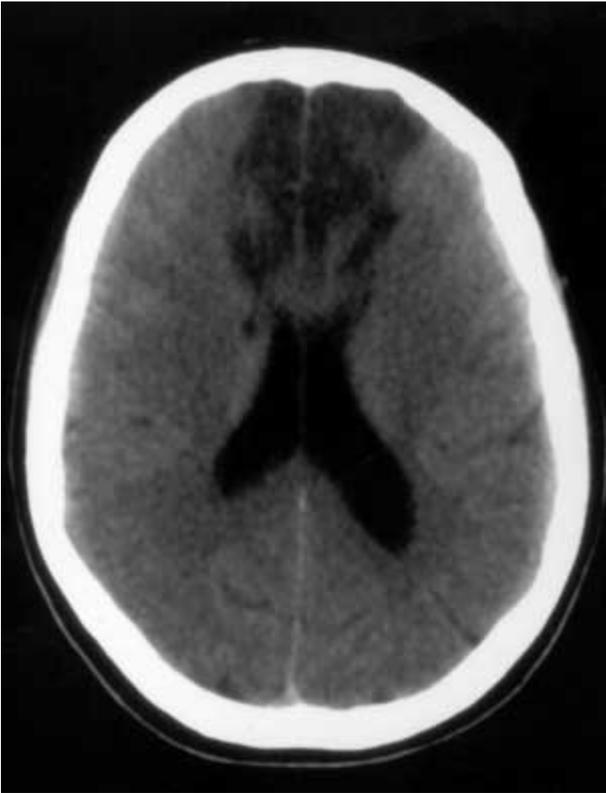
CT scan of the brain without contrast, at admission, showing bilateral hypodensities in the territory of both anterior cerebral arteries.
